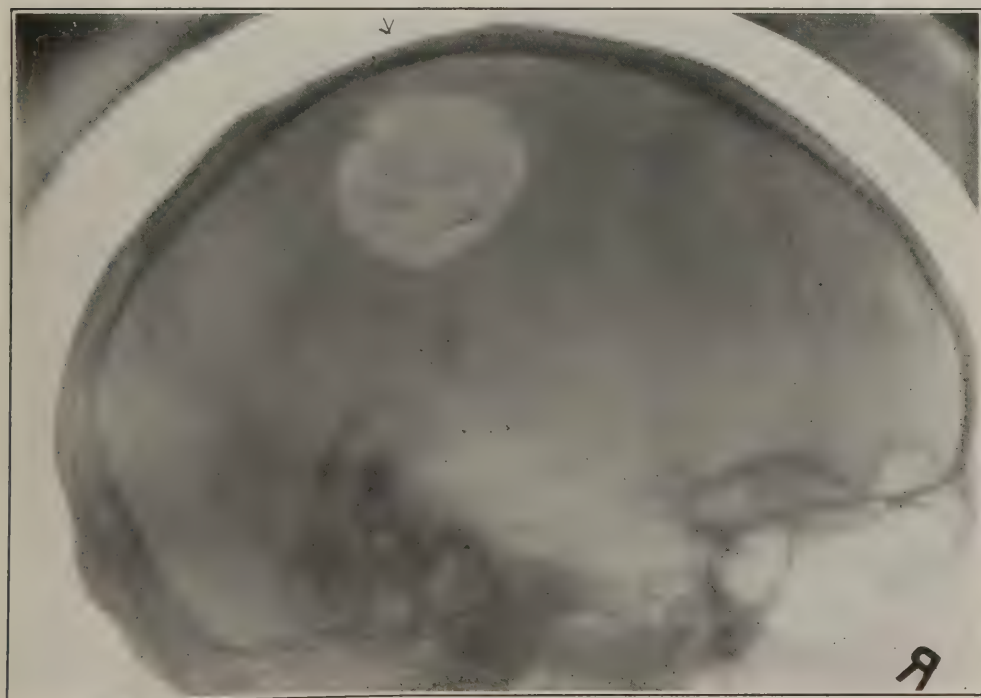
Roentgenogram of head shown in Figure 37, after repair. The bone graft is clearly outlined
